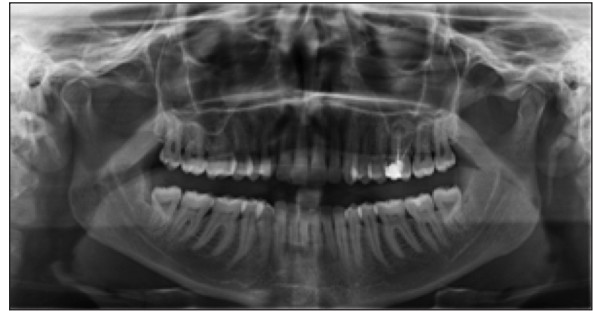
Pretreatment panoramic radiography showing moderate bone loss.
